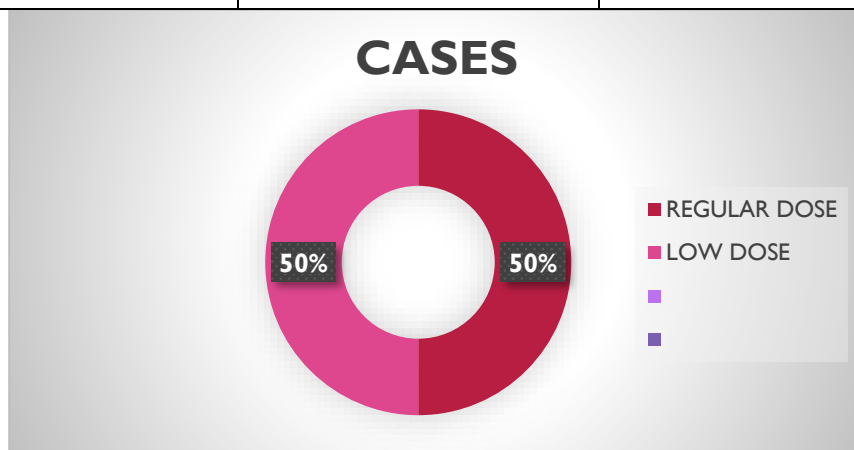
The Study selected among 50 peoples comes for Follow-up CT imaging for that peoples are scanned in different doses one is regular dose and another one is low dose CT imaging among 50% is regular dose and another 50% is low dose CT imaging.
